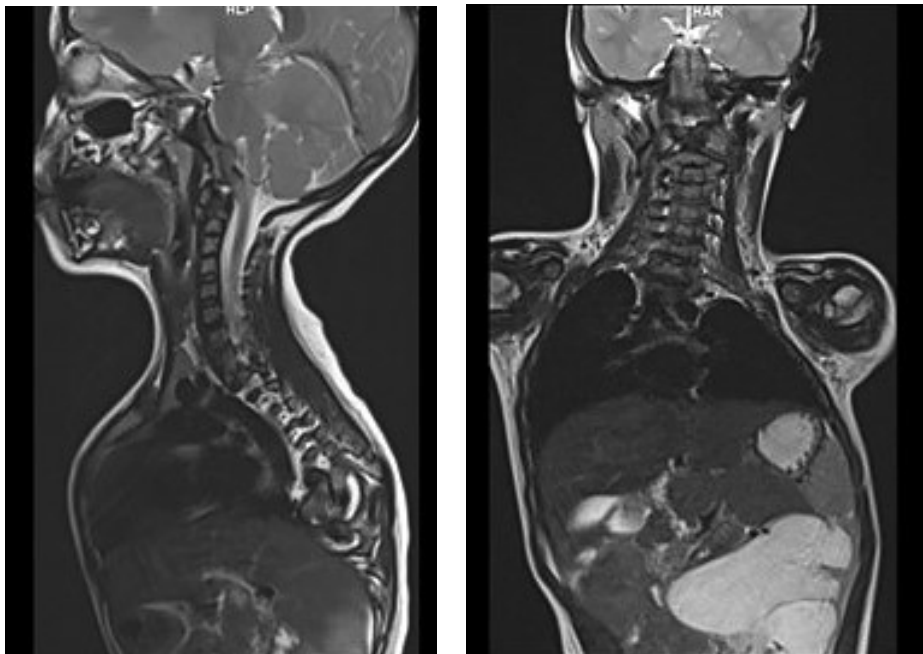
Magnetic resonance imaging (MRI) of cervical spine
